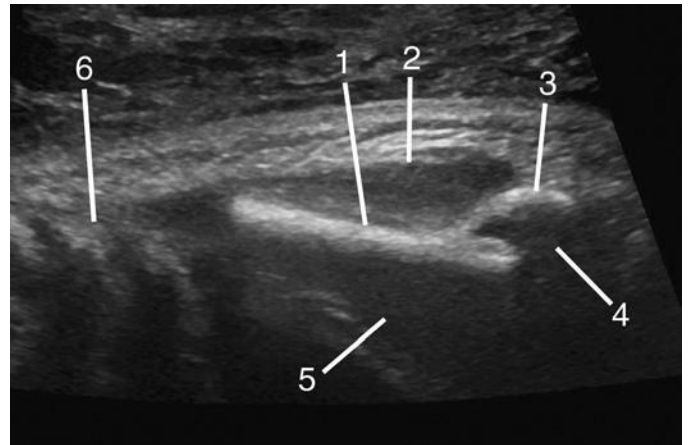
Parasagittal sonogram of the scapula. 1, infraspinous fossa; 2, infraspinatus muscle; 3, scapular spine; 4, supraspinatus muscle; 5, subscapularis muscle; 6, ribs in short axis.
